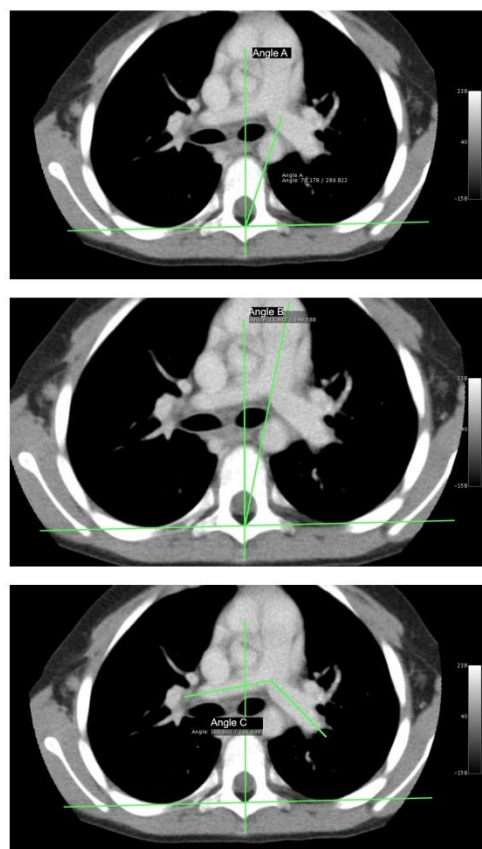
a–c: CT scan measurements at the level of the main pulmonary trunk (outflow tract). The horizontal baseline represents a line between the transverse processes of the vertebra. a: “Anti-clockwise rotation of the aorta”—the angle between the midpoint of the aorta and the horizontal baseline (angle A). b: “Pulmonary outflow tract rotation”—the angle of the main axis of the pulmonary trunk with the mid sagittal plane (angle B). (c) “Pulmonary bifurcation angle”—the angle between the two main pulmonary arteries (angle C).
